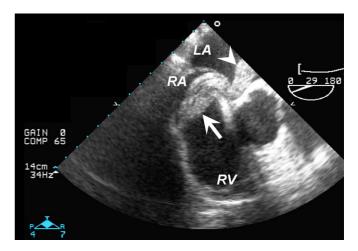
Trans-oesophageal echocardiography showing a large impending paradoxical embolism from the right atrium (*RA*; *arrow*) passing through the patent foramen ovale into the left atrium (*LA*; *arrow head*). *RV*: right ventricle.
